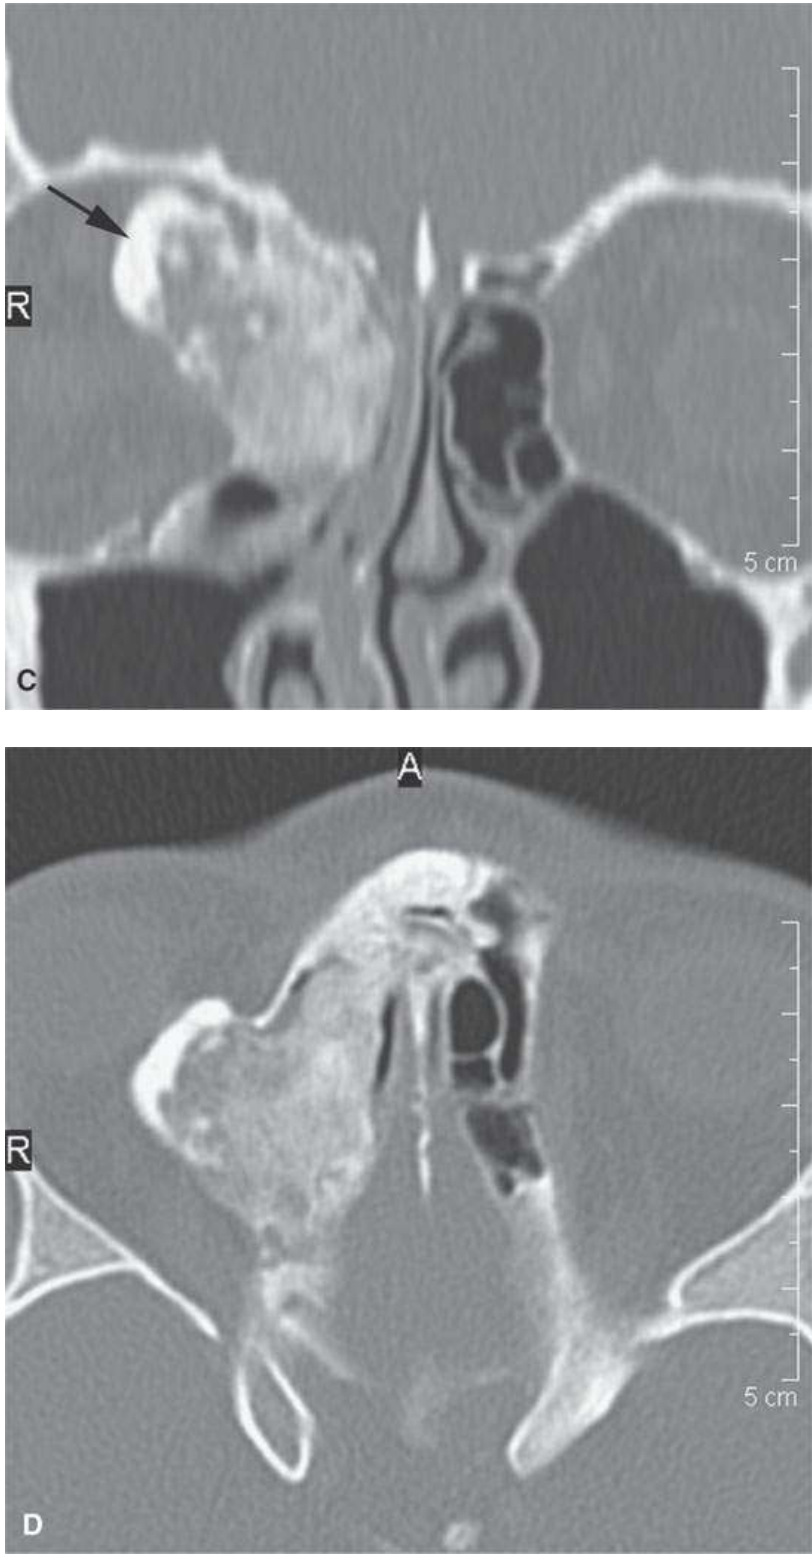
The obvious area of signal void is seen on the magnetic resonance images (T1-weighted non-contrast enhanced in A and T2 weighted in B by the arrows), but the nature of the remaining matrix and true nature of the signal void area is not clear (*arrow*) until viewing the non-contrast-enhanced computed tomography in (C) and (D). This was diagnosed pathologically as an osteoma with elements of osteoblastoma.
